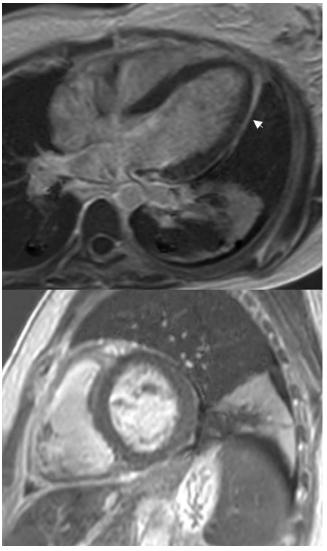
MRI scan of the heart shows minimal pericardial effusion and enhancement of the pericardium up to the left free ventricular wall (arrow). The upper panel is the horizontal long axis view and the lower panel the short axis view. MRI: magnetic resonance imaging.
